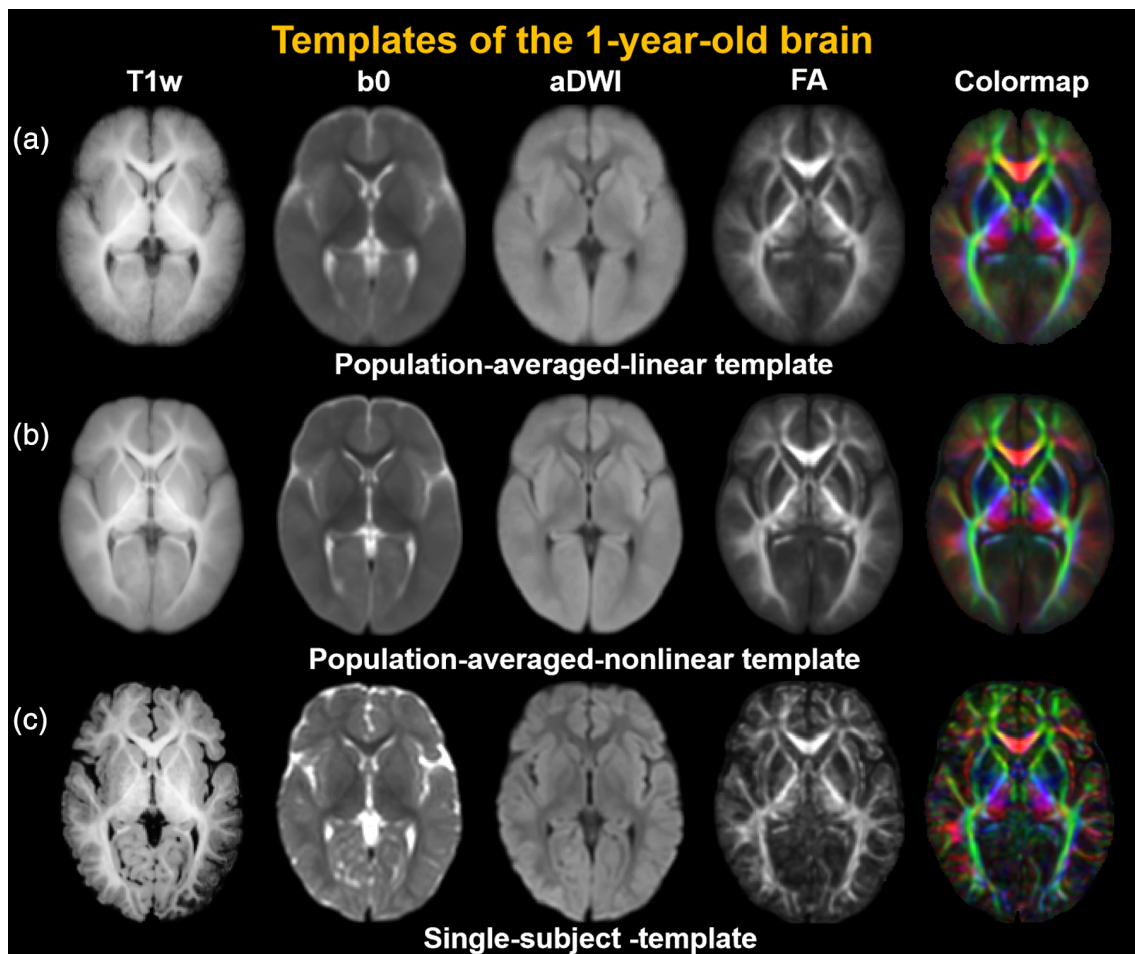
Population-averaged-linear (a), population-averaged-nonlinear (b), and single-subject (c) templates for 1-year-old brains. From left to right: T1-weighted (T1w) images, b0 images, averaged diffusion weighted image (aDWI), fractional anisotropy (FA) map, and DTI orientation-encoded colormaps.
